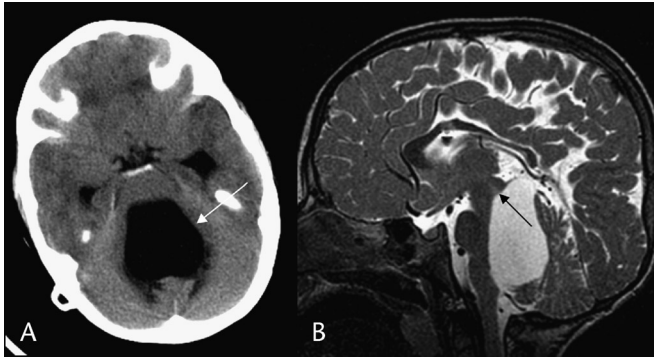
Isolated fourth ventricle in shunted PHH. Noncontrast CT (A) shows marked enlargement of the fourth ventricle (white arrow) with surrounding edema. Sagittal T2 (B) image further delineates the extent of the trapped fourth ventricle, including the deformation of the brain stem and cerebellum, the closed aqueduct (black arrow), and the small third and lateral ventricles.
